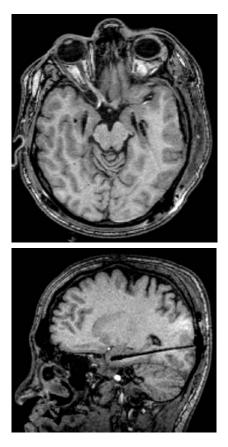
Axial and sagittal MR imaging after stereotactic insertion of DBS leads bilaterally in amygdala and caput hippocampi. An additional subdural grid electrode has been placed over the left temporal lobe
